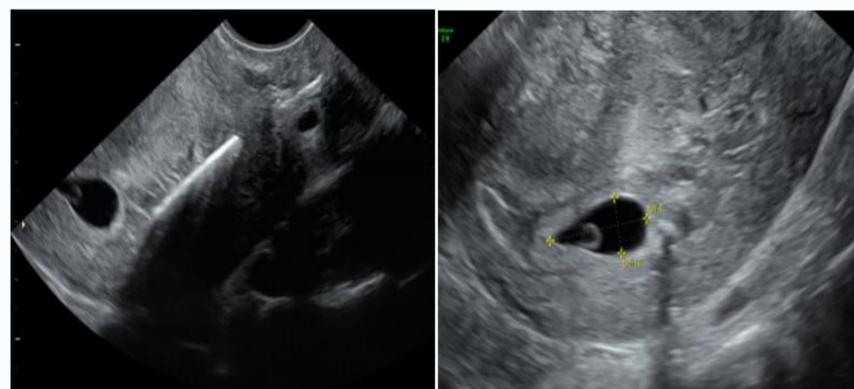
IUD and pregnancy seen via ultrasound during the attempt to remove the device with Kelly and Kocher forceps
